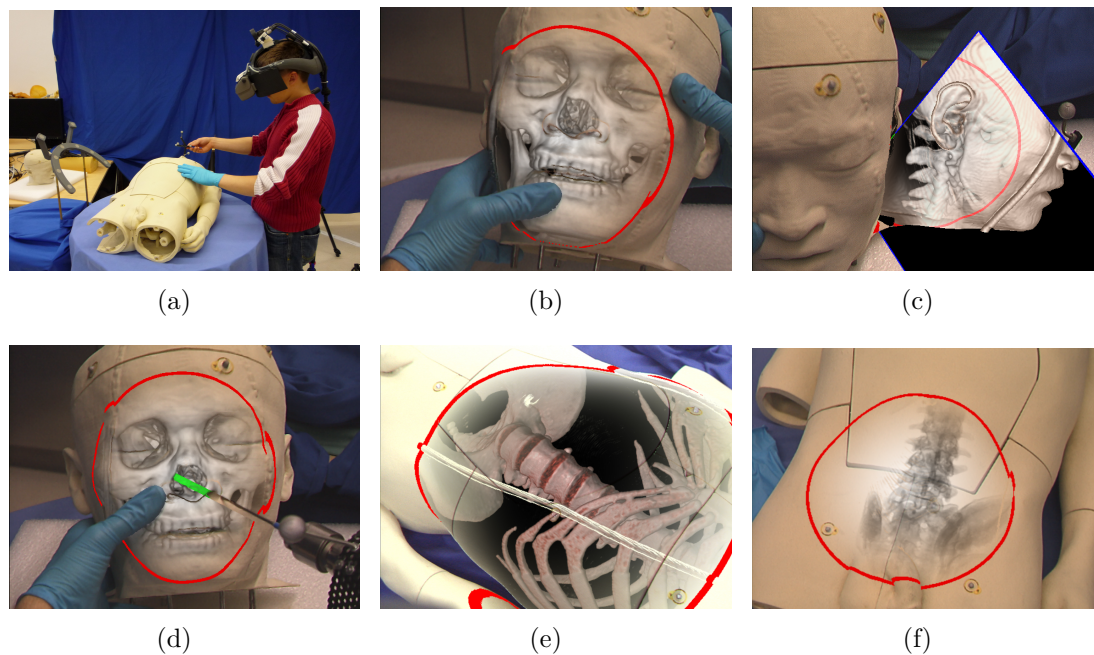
(a) Experiment setup. User is wearing the HMD, holding a tracked pointer in his hand which is used to control virtual mirror (see (c)). (b-f) Focus and context renderings of VKH head and thorax datasets. (b) Hand Occlusion handling, (c) Virtual mirror view of lower head and neck region (d) Insertion of virtual drill and correct hand and instrument occlusion handling (e) Shaded volume rendering inside large abdominal focus region (e) Virtual X-ray (DRR) rendering of lower spine and hip focus region.
